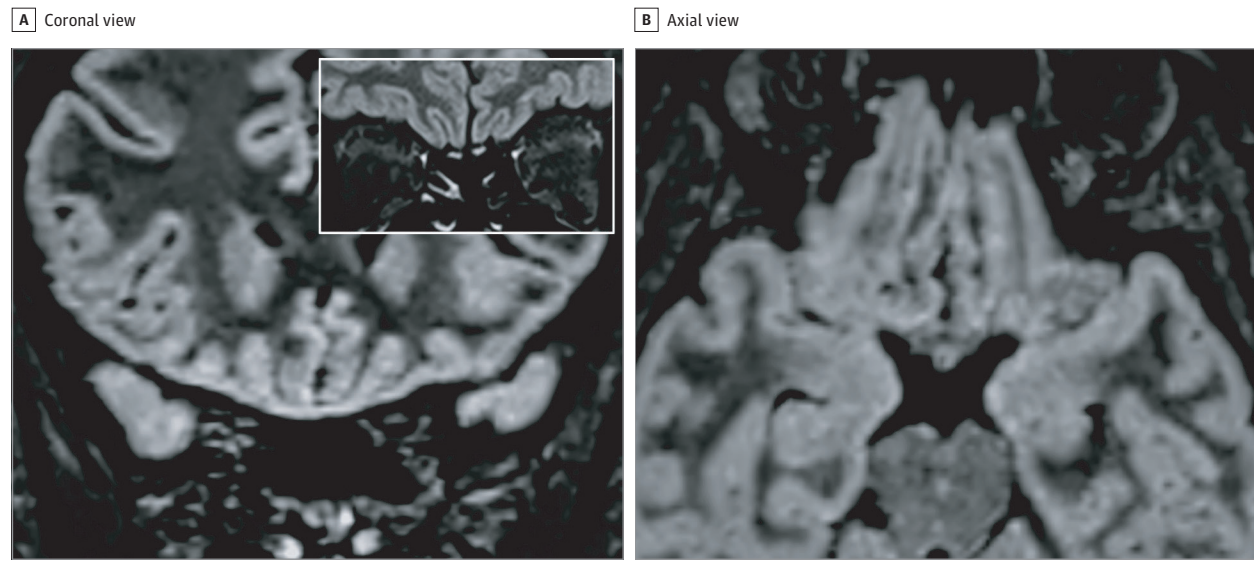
Brain Magnetic Resonance Imaging Alterations in a Patient With Coronavirus Disease 2019 (COVID-19) Presenting With Anosmia 4 Days From Symptom Onset
